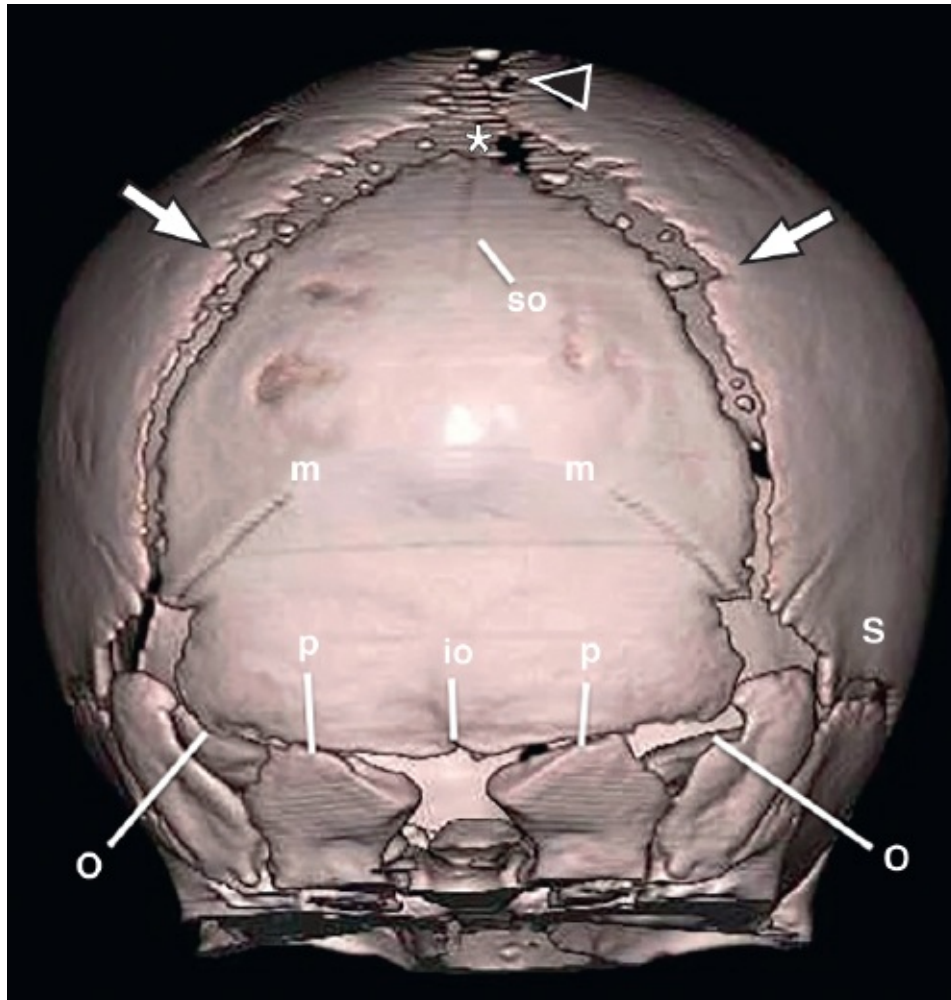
Transient sutures of the occipital bone visualized on a three-dimensional surface rendering of a 1-month-old boy's head CT (posterior view). Markings are as for Figures 1.1 and 1.2 but additional sutures marked include "so", "m", and "io" for superior occipital, paired mendosal sutures, and inferior occipital sutures, respectively.
